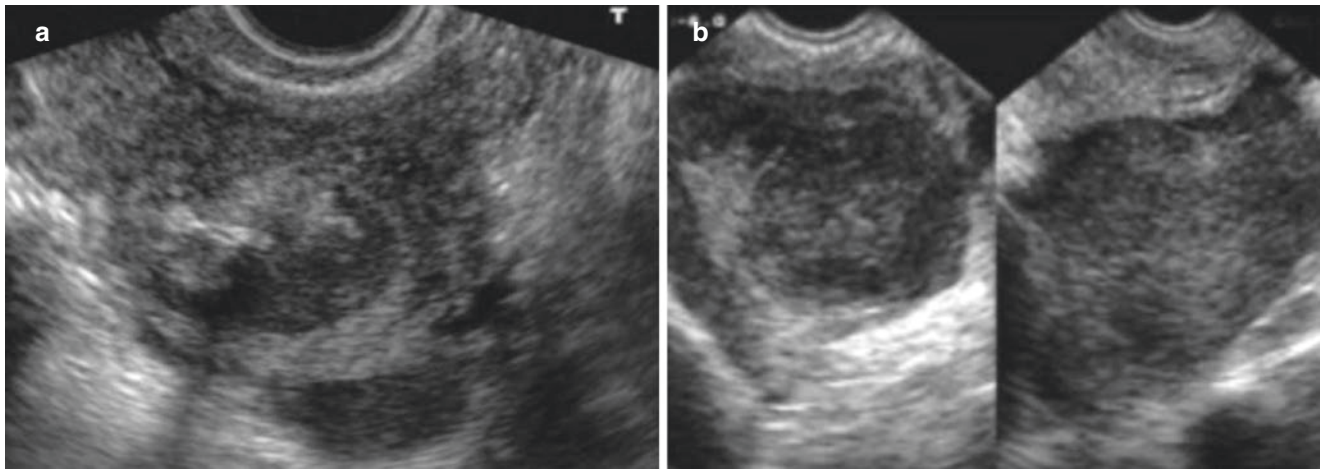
Ruptured ovarian endometriotic cyst. (a) A 36-year-old patient represented abdominal pain for 3 hours with a history of dysmenorrhea. Emergency ultrasonography shows an irregular and heterogeneous hypoechoic mass in the left adnexa area, without an obvious
